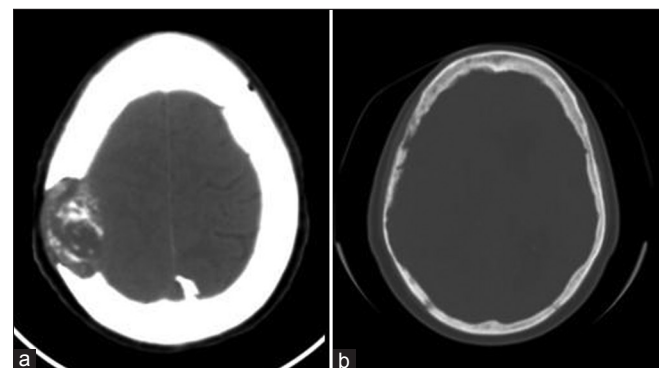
CT bone window of a patients with breast cancer. (a) Multiple irregular and lytic lesions in the calvarium (b) single bony destruction with dural metastatic involvement
